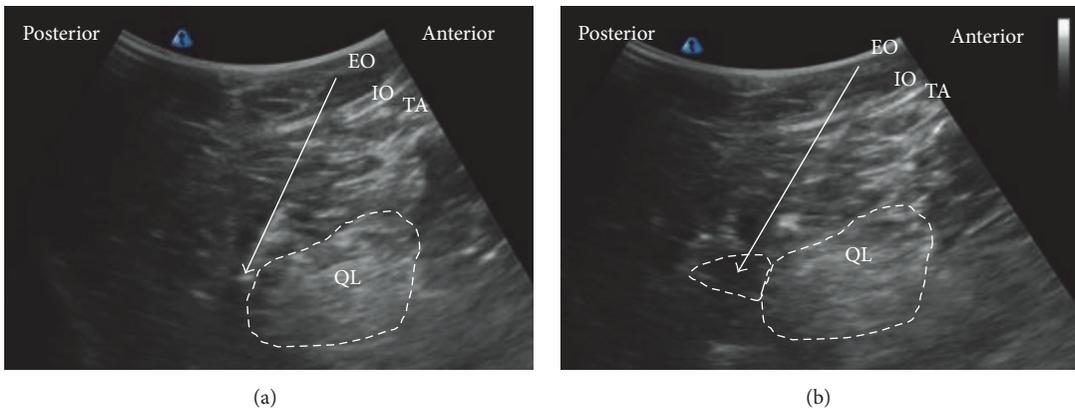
Ultrasound images of posterior QL. (a) Preinjection and (b) postinjection. EO: external oblique muscle, IO: internal oblique muscle, TA: transversus abdominis, QL: quadratus lumborum, white arrow: needle trajectory, and white dotted line: spread of local anesthetic.
